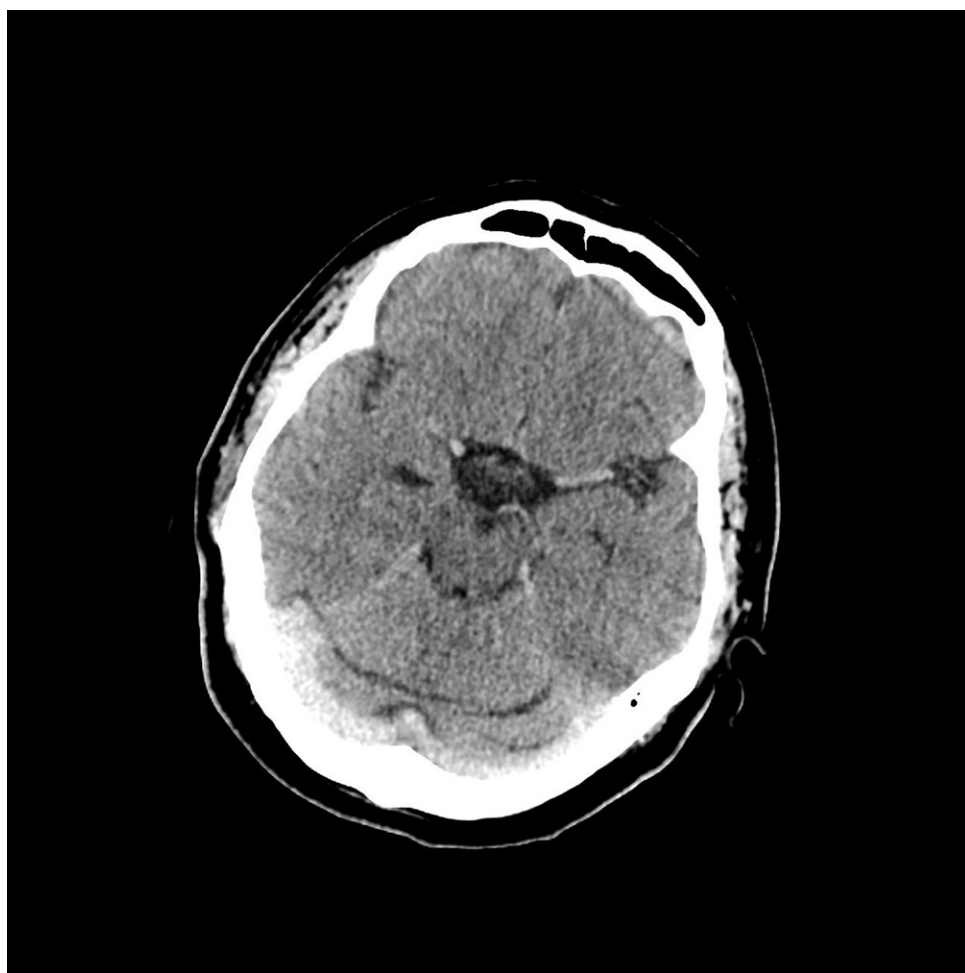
Computed tomography of the brain with hypertensive image of the middle cerebral artery.
